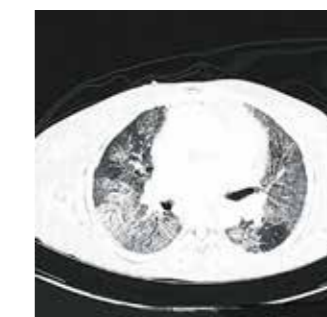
High-resolution computed tomography chest showing diffuse interstitial involvement
